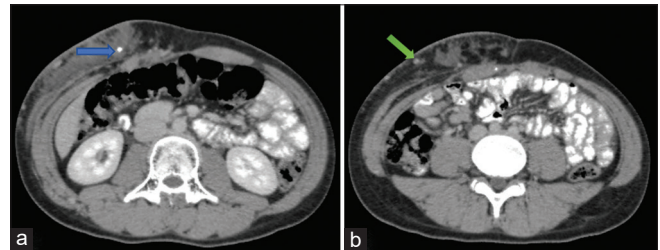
Computed tomography (a) showing calcific focus (blue arrow) suggestive of phlebolith, signifies that it is a venous malformation, and (b) an enhancing vein (green arrow) running through the lymphatic channels in the anterior abdominal wall on the right side
